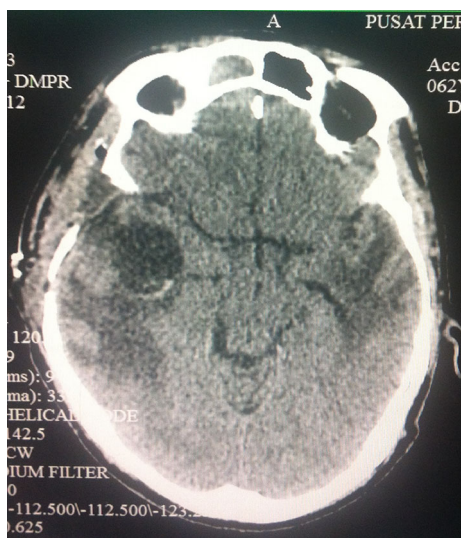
Axial view of CT brain post first craniotomy in February 2013 showed cystic lesion at right temporal lobe in communication with craniotomy site
